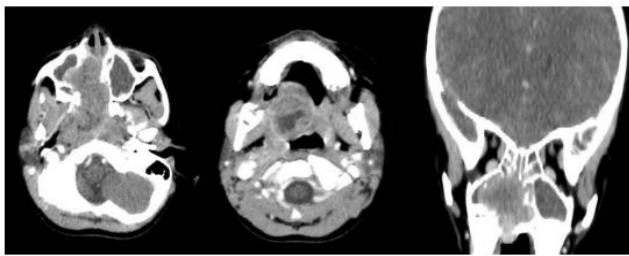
Axial CT scan revealing a tissue mass centered in the right maxillary sinus, extending into the adjacent parapharyngeal space on the same side.
